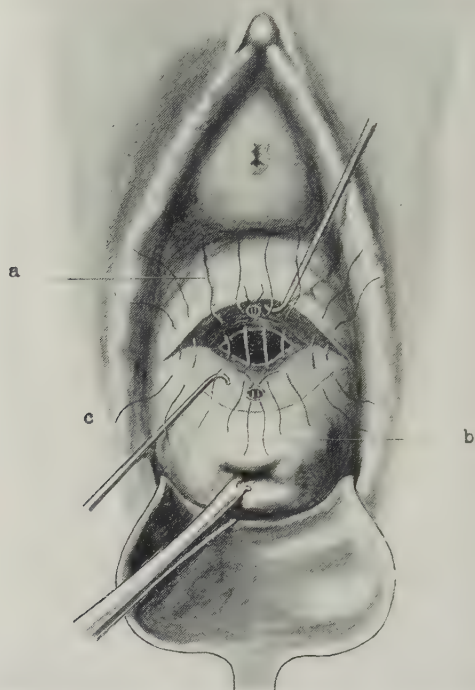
OPERATION FOR VESICO-UTERINE FISTULA BY EXPOSING AND SUTURING THE VESICAL AND UTERINE ASPECTS OF THE FISTULA THROUGH THE TEMPORARILY, TRANSVERSELY DIVIDED ANTERIOR FORNIX — I — Champney's Operation; — The bladder opening is exposed through a transverse vaginal incision in the anterior fornix — through which the bladder is dissected from and above the cervix, in the uterovesical plane — exposing the vesical and cervical openings: — a, Non-penetrating, buried sutures closing the bladder opening; — b, sutures closing the cervical fistula; — c, some of the sutures closing the main wound.
